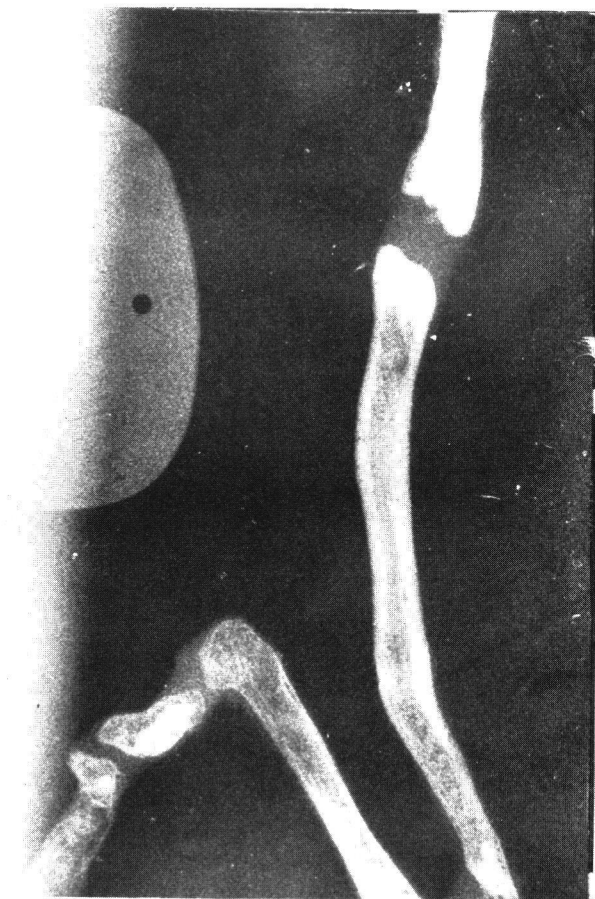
A dental X-ray plate placed against the process, dissected free as in Fig. 3 and exposed, shows discontinuous ossification. At the top is the styloid process; the greater horn and thyro-hyoid ligament (containing ossification) occupy the lower left corner of the picture.
